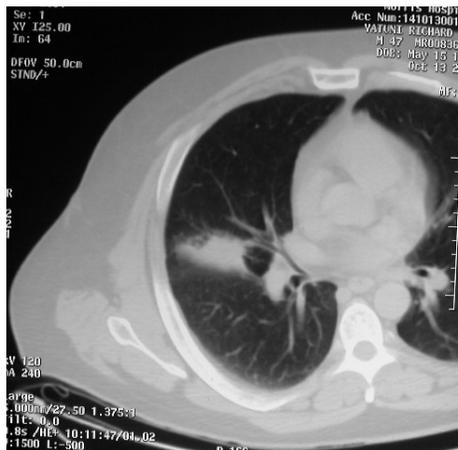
CT scan shows a fissural, midzonal, right middle lung mass or infiltrates (arrow).
